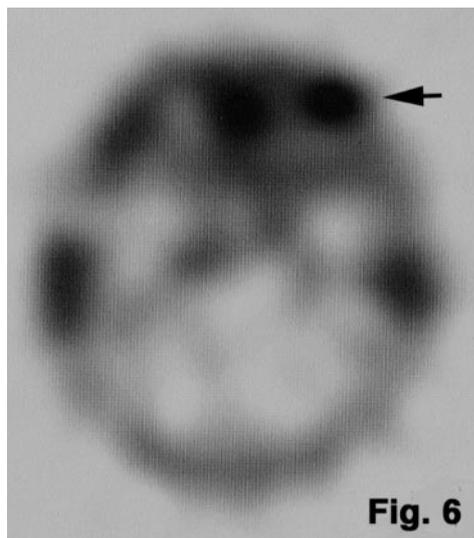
Octreotide scintigraphy of a melanoma tumor shows pathologic uptake of [111-indium-DTPA-D-Phe1]-octreotide in the left eye of a patient with a choroidal melanoma 15 mm in height (arrow). The other eye showed no positivity.
